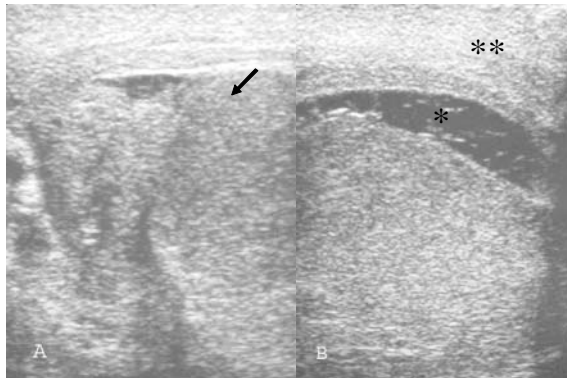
A 70 year old man presented with a left testicular mass. (A) Scrotal ultrasound shows normal size of the right testis with a 1 cm well-defined hypoechoic mass (↑). (B) Enlarged left testis with a lobulated hypoechoic mass (↑↑) was noted. Minimal fluid in the scrotal sac was observed. The epididymis and covering skin were normal bilaterally. Pathologic study revealed non-Hodgkin lymphoma
